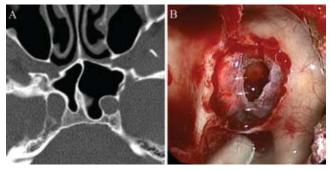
Axial CT scan obtained preoperatively (A), and intraoperative endoscopic photograph obtained following tumor resection (B) in a patient with acromegaly demonstrating increased caliber and tortuosity of the ICA. In panel B, the right ICA can be visualized immediately behind the sellar dura (white arrows). The location and caliber of the ICA substantially increase the risks associated with dural opening and tumor resection.
